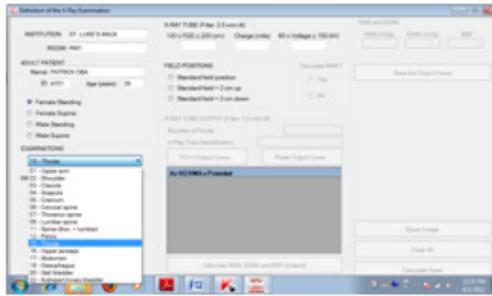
Definition of adult patient data, posture and view of possible X-ray examinations
